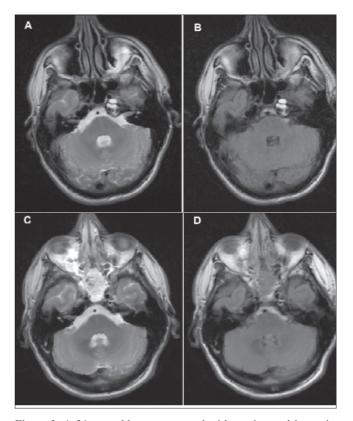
A 34-year-old man presented with vertigo and intermittent left-sided facial and abducens palsy. Axial T2- (A) and T1- (B) weighted MRI demonstrating a petrous apex lesion characterized by a central region of increased intensity and a peripheral rim of markedly decreased signal intensity on both sequences corresponding to a cholesterol granuloma. Axial T2- (C) and T1- (D) weighted MRI obtained 1 year postoperatively revealing a clear resolution of the lesion and absent central hyperintensity. Endoscopic inspection depicted a complete epithelial-layered cyst cavity, no secretion.
